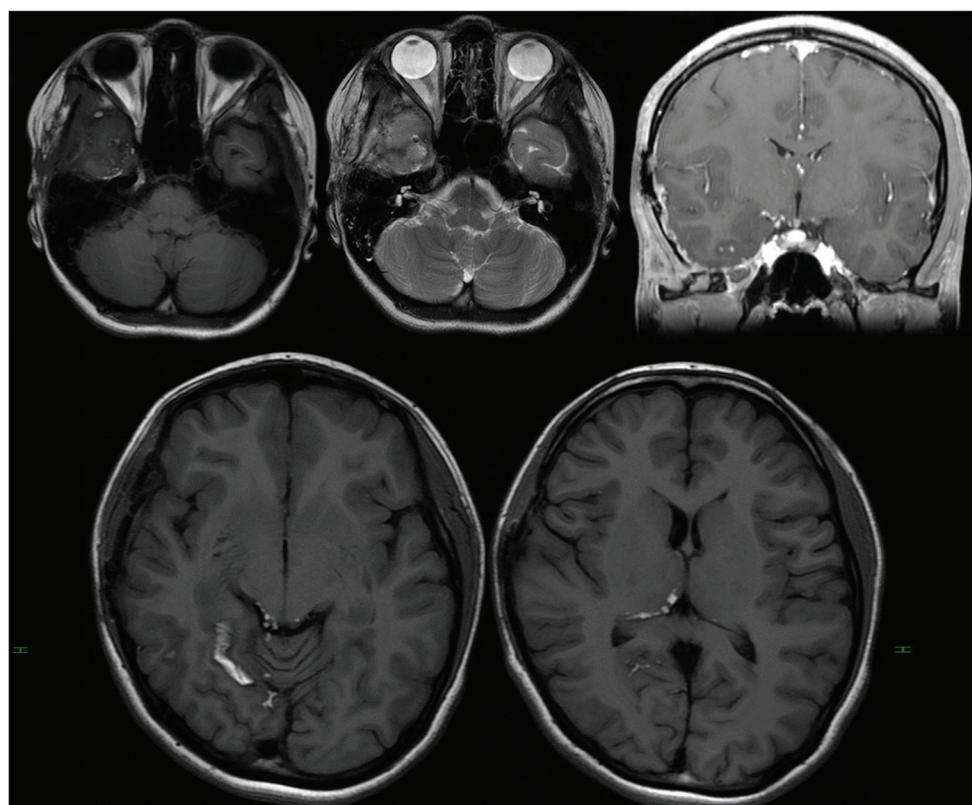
One-month postoperative magnetic resonance imaging images show complete removal of the ruptured dermoid cyst, with fat droplets in the subarachnoid space, no change in their sites, and no hydrocephalus.
